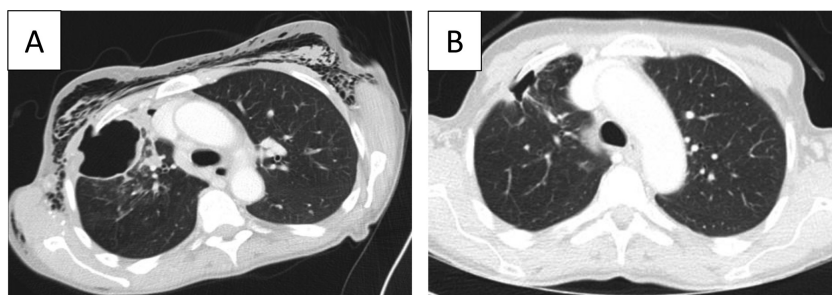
Evolution of Chest CT findings. A- CT at admission with a right upper lobe (RUL) cavitary lesion with a chest wall fistula. Extensive subcutaneous emphysema. B- CT after 2 months, revealing improvement of the lung cavitation and fistula on the RUL and no subcutaneous emphysema. The metastatic lesion submitted to thermal ablation is not present.
